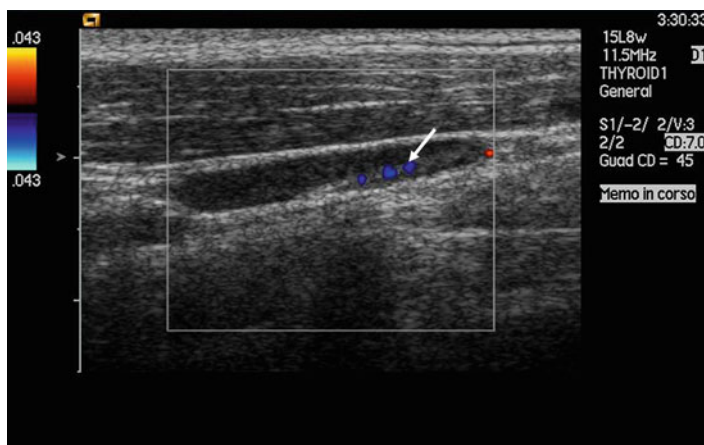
Normal lymph node. The shape is elongated, the hilum is clearly visualized as a hyperechoic streak, and regular central vascular signals are revealed by color-Doppler examination. A hyperechoic border limits the mildly hypoechoic structure
